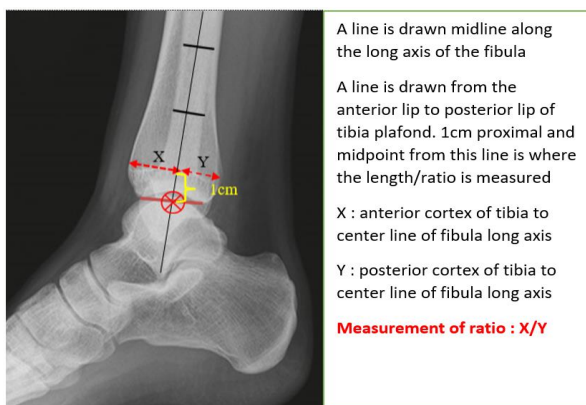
True lateral view ankle radiograph labelled with lines for measurements
